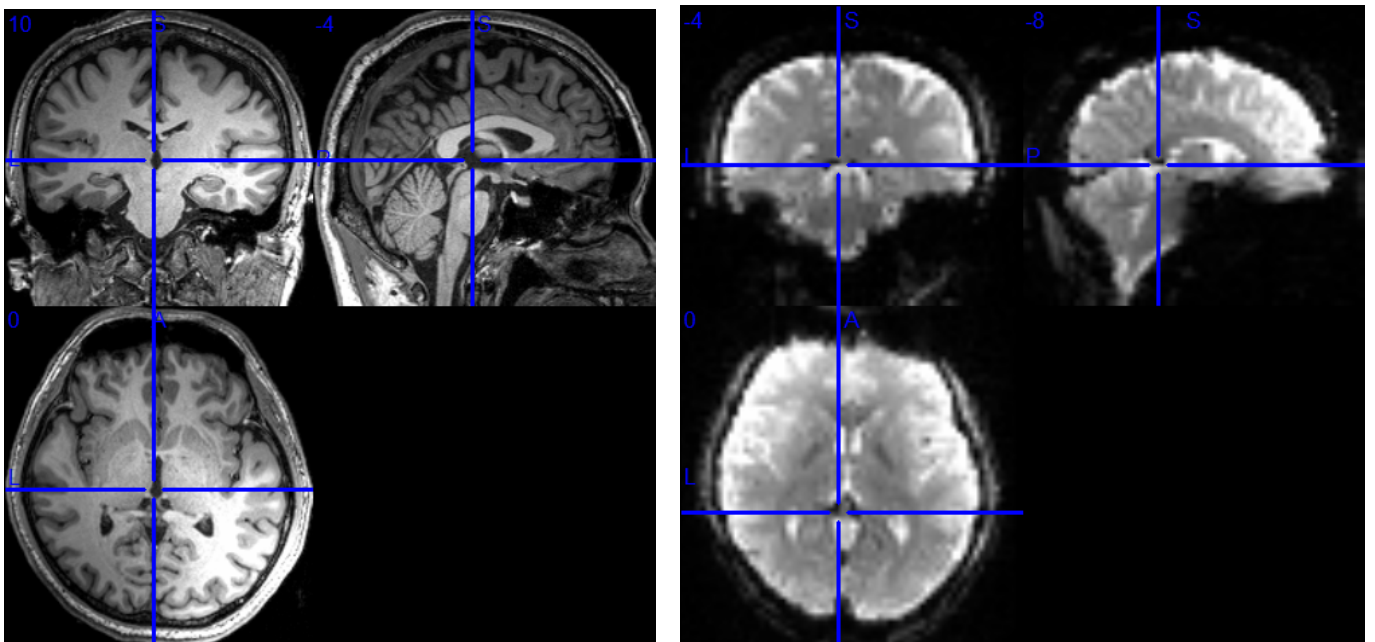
tACS (1 mA, 10 Hz) results – MRI T1 (left) & MRI EPI (right)
